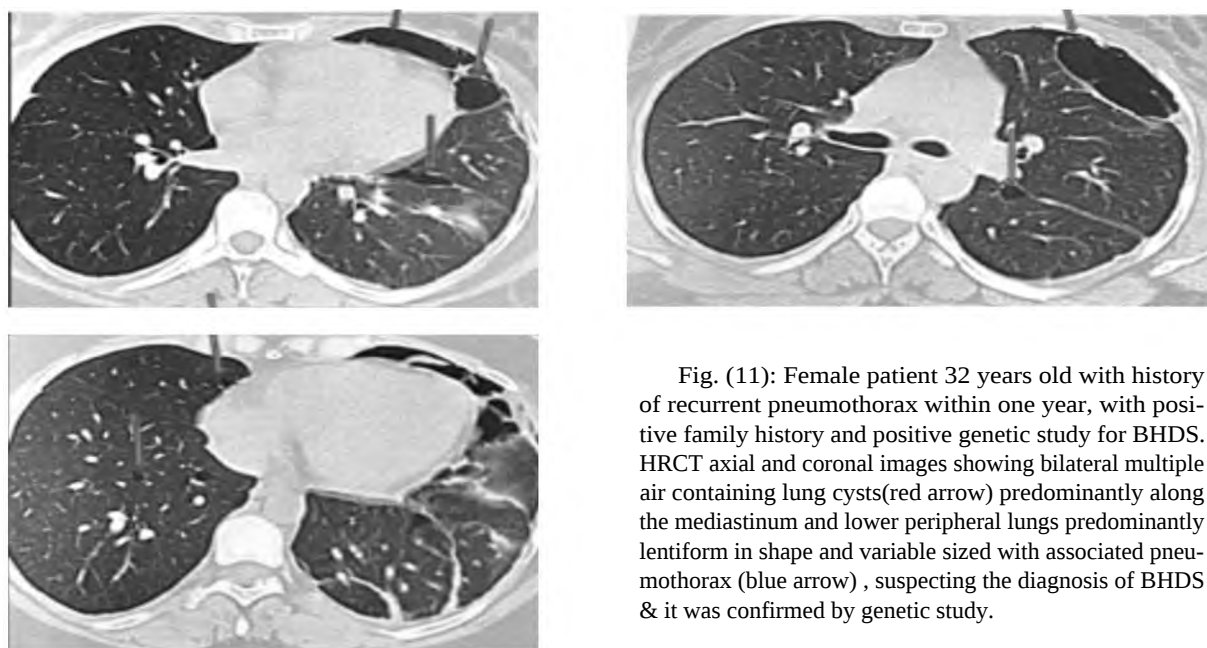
Female patient 32 years old with history of recurrent pneumothorax within one year, with positive family history and positive genetic study for BHDS. HRCT axial and coronal images showing bilateral multiple air containing lung cysts (red arrow) predominantly along the mediastinum and lower peripheral lungs predominantly lentiform in shape and variable sized with associated pneumothorax (blue arrow), suspecting the diagnosis of BHDS & it was confirmed by genetic study.
